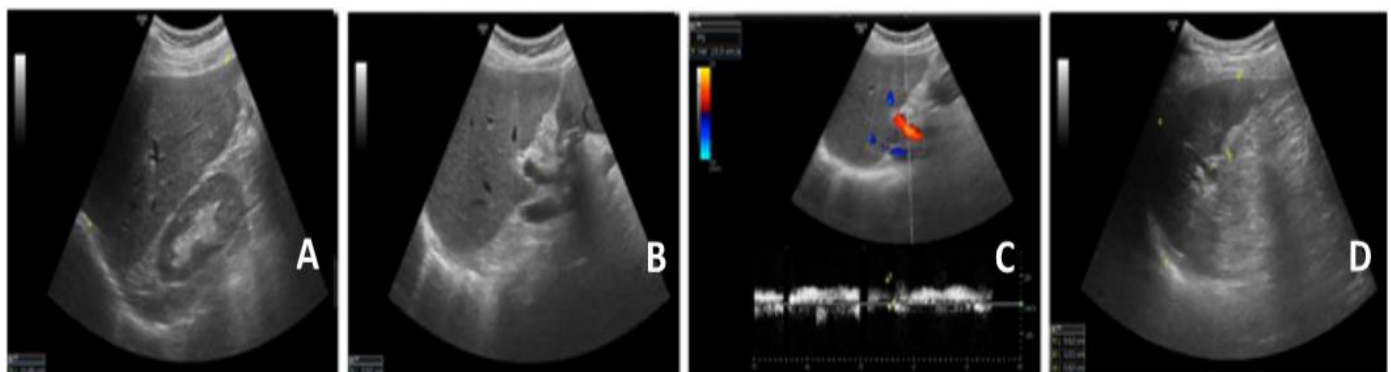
(A-D): A female patient 40 year old post DAAS therapy with no EV and platelet count 176000 n/u.l. Abdominal ultrasonography reveals early cirrhotic liver with liver span 15.86cm (A), PV diameter 9.2mm (B), PVV 13.8cm/sec (C), longitudinal and transverse splenic diameters 9.62cm and 5.01cm. $SI=9.62 \times 5.01=48.19$, $SPI=48.19/13.8=3.49$, $PCSDR = 176000/96.2=1829.5$
